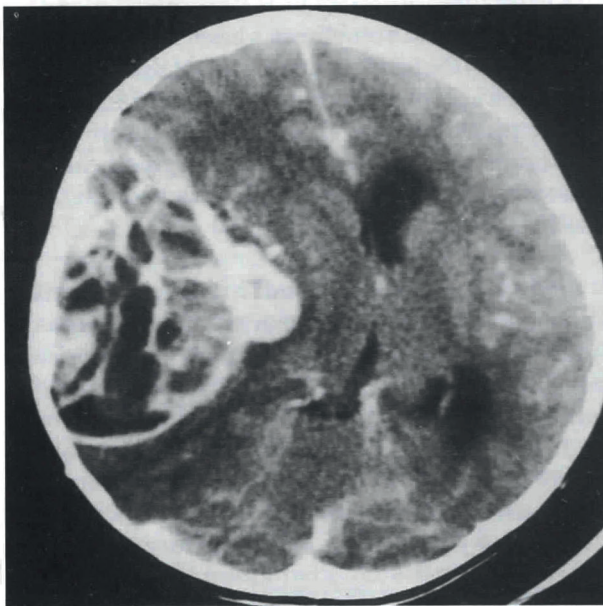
Axial CT scan showing a well circumscribed, irregular contrast enhancing mass with nidus.
